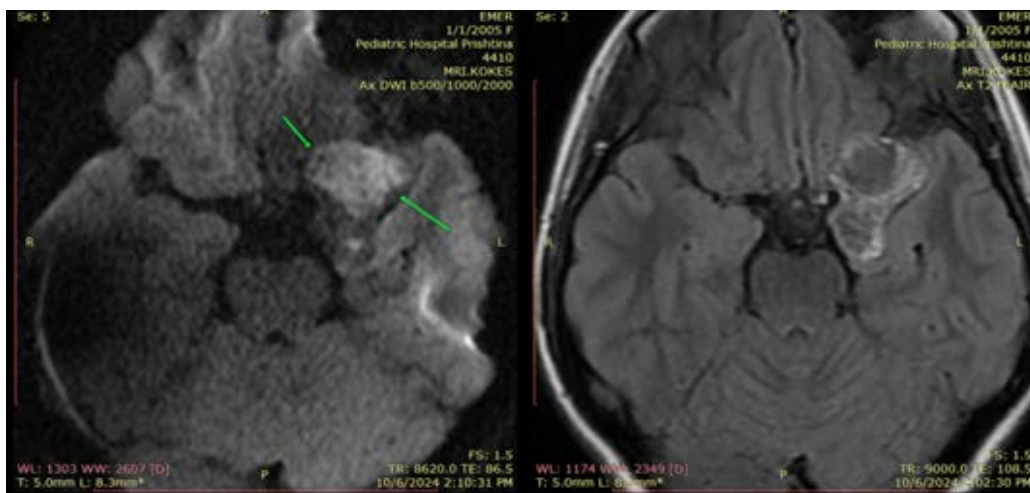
A 19-year-old female with epidermoid cyst. FINDINGS: MRI of the brain demonstrates hyperintense signal on DWI sequence consistent with an epidermoid cyst, with marginal hyperintense signal on FLAIR sequence. TECHNIQUE: Axial MRI, DWI sequence (TR 9000 ms, TE 108.5 ms), FLAIR sequence, 5 mm slice thickness, following administration of 12 mL of Gadopentetate dimeglumine.
